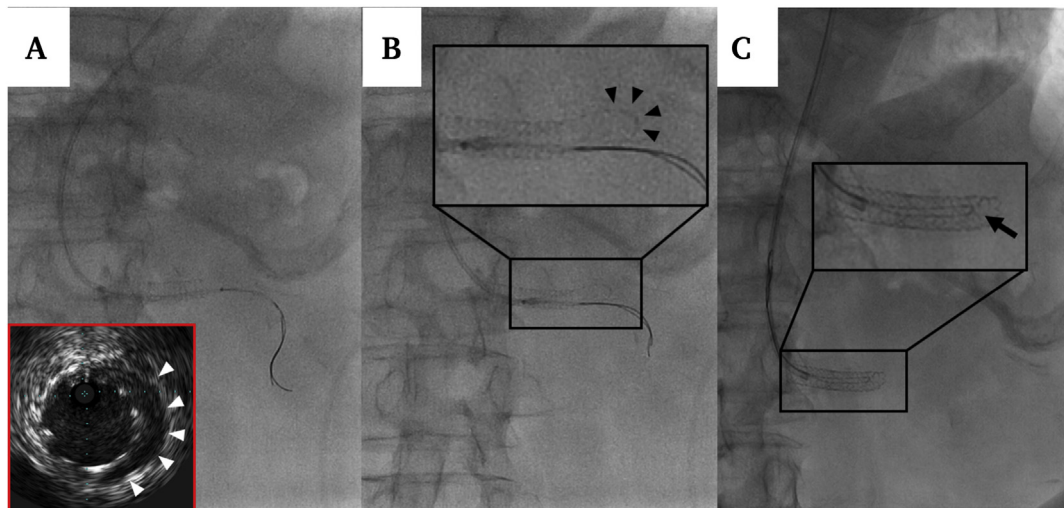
(A) Post-stent implantation. The Prowater guidewire was crossed in addition to the Filtrap guidewire. The red box includes the intravascular ultrasound image, showing stent malapposition at the stent distal edge (arrowheads). (B) During filter wire retrieval, the second guidewire was pulled simultaneously, forming a loop (arrowheads show the loop of the flipped guidewire). (C) The second guidewire trapped at the distal edge of the stent accompanying stent edge deformation (arrow).
